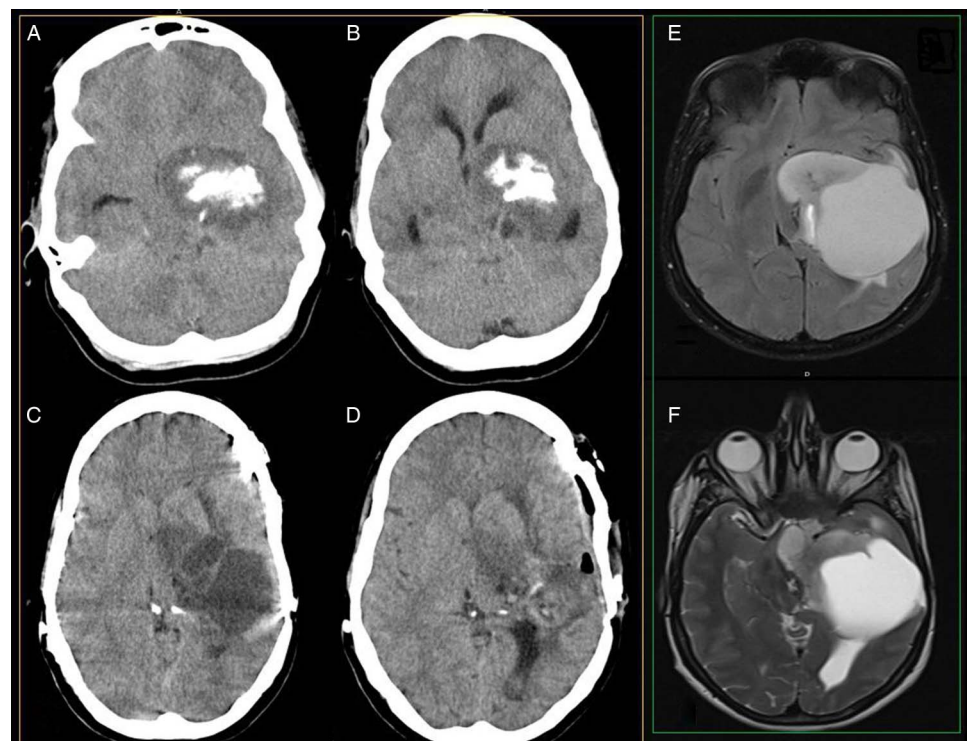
(A–C) Left calcified temporal mass with involvement of the thalamus and medial aspect of the left temporal lobe. (D) Cranial CT scan after first surgery. (E and F) MRI with gadolinium before second surgery: voluminous 6.5 cm mass in the left fronto temporal lobe, with cystic appearance.
